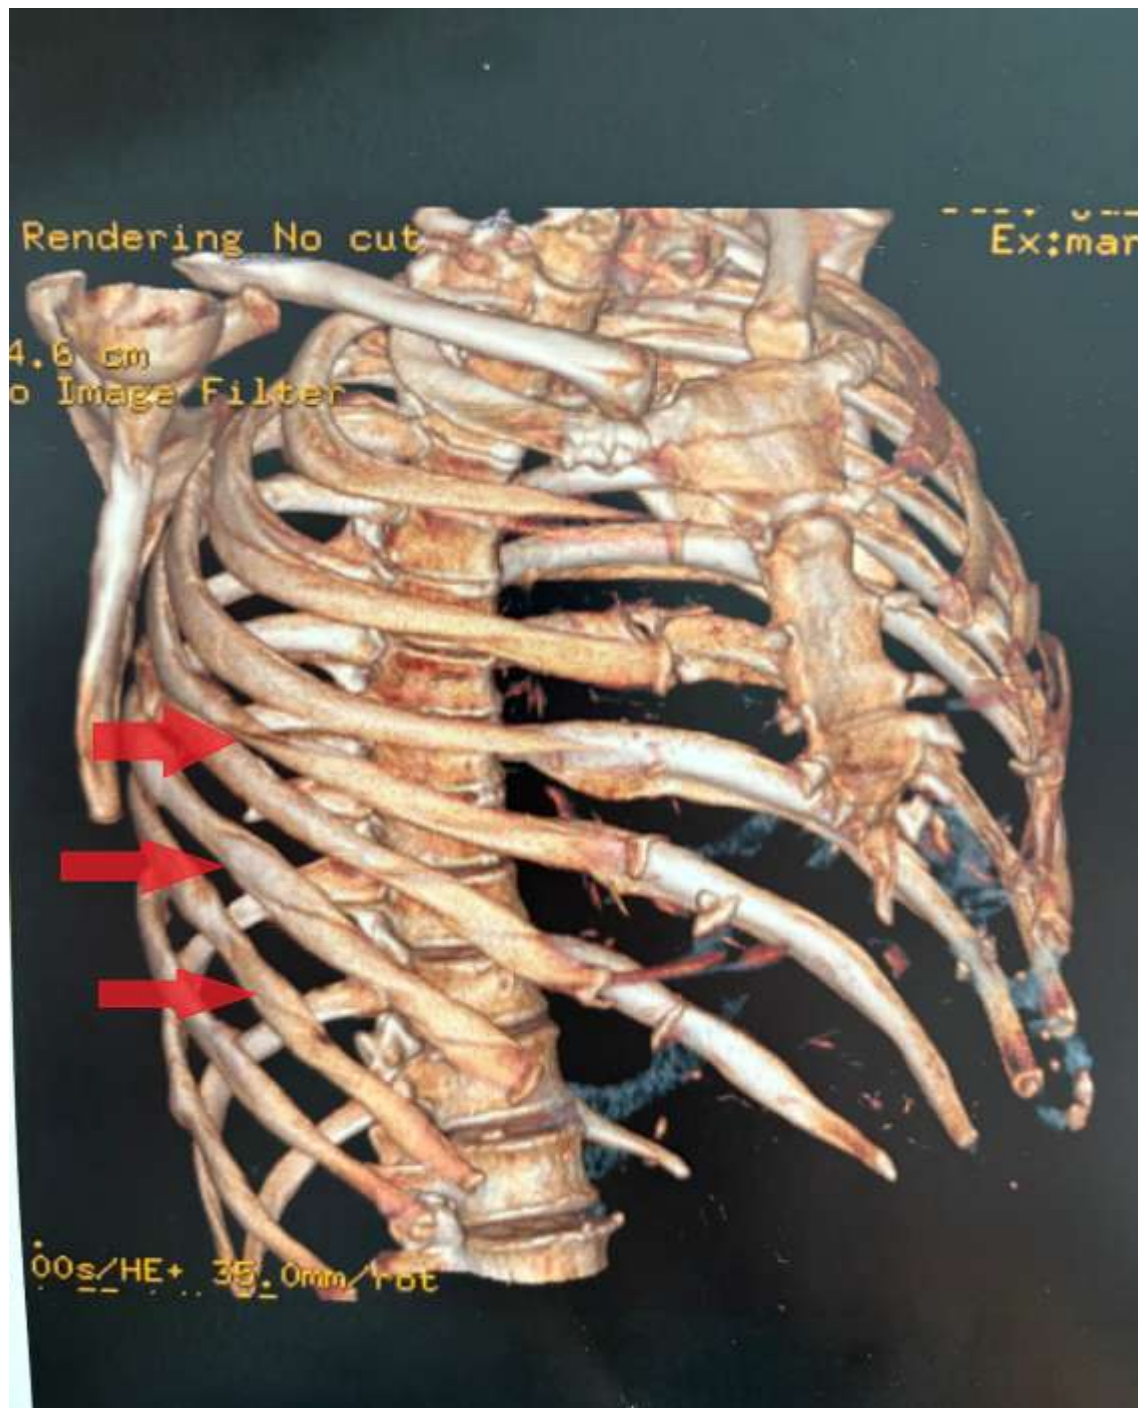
Three-dimensional reconstruction by computed tomography (CT) showing multiple fractures of the right costal arches (6th, 7th and 8th ribs) (arrows).
